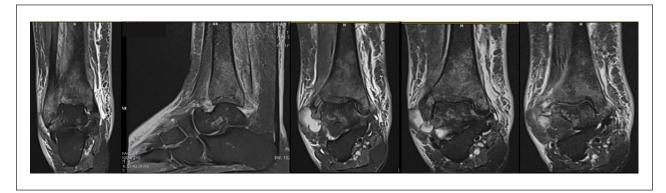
MRI of the right lower extremities showed thick fluid collection with heterogeneous signal intensities (complex collection) in subtalar joint and signal changes in most hind foot bones and some midfoot. There was narrowing of the tibiotalar joint space and destruction of the tibial subchondral bone (at the tibia talar dome), talus bone, and the fibular lateral malleolus. Tibial, fibular, talus, and mild calcaneus bone marrow edema surrounding the tibial lesions was seen with edematous infiltration of the per malleolar soft tissues with skin discontinuation suggesting an ulcer. There was diffuse marrow infiltration in the distal tibial (epiphysial-metaphyseal region), talus and distal epiphysis of fibula.
